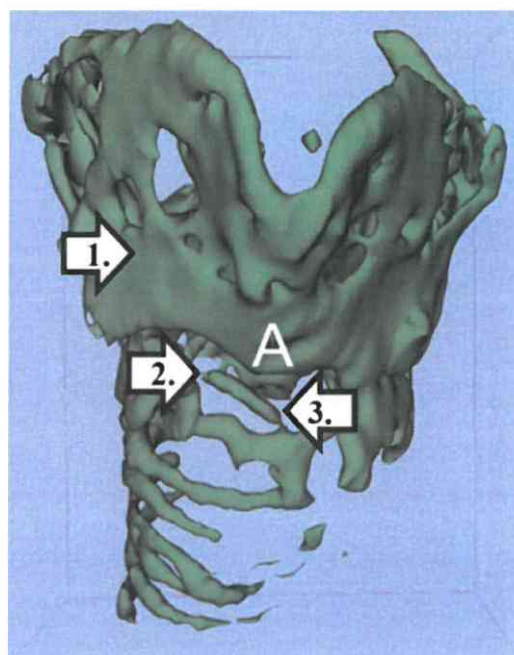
Three-dimensional computed tomography reconstruction of the laryngeal framework (patient 2, 6th postoperative month). 1: the remnant of the thyroid cartilage; 2: the cricoid cartilage is resected; 3: the rotated tracheal rings (sagittal view). [Color figure can be viewed in the online issue, which is available at www.laryngoscope.com.]
